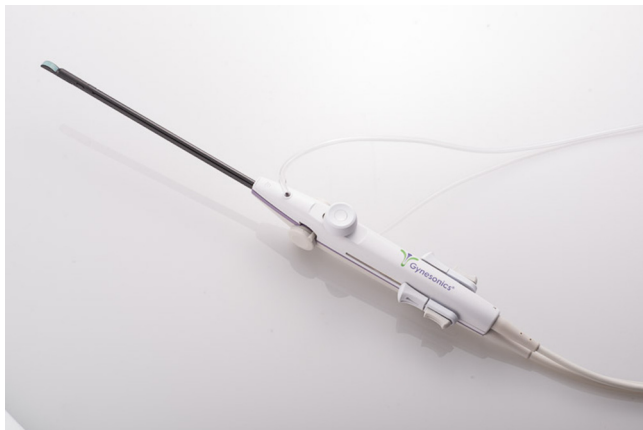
Intrauterine sonography probe.
